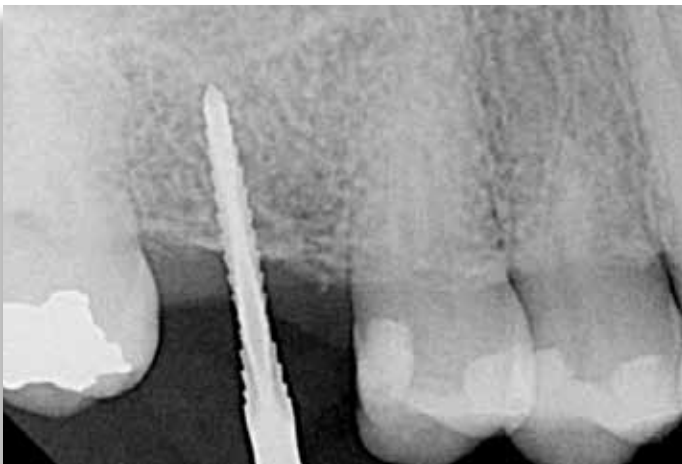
A digital radiograph is taken to determine angulation of the primary drill.
